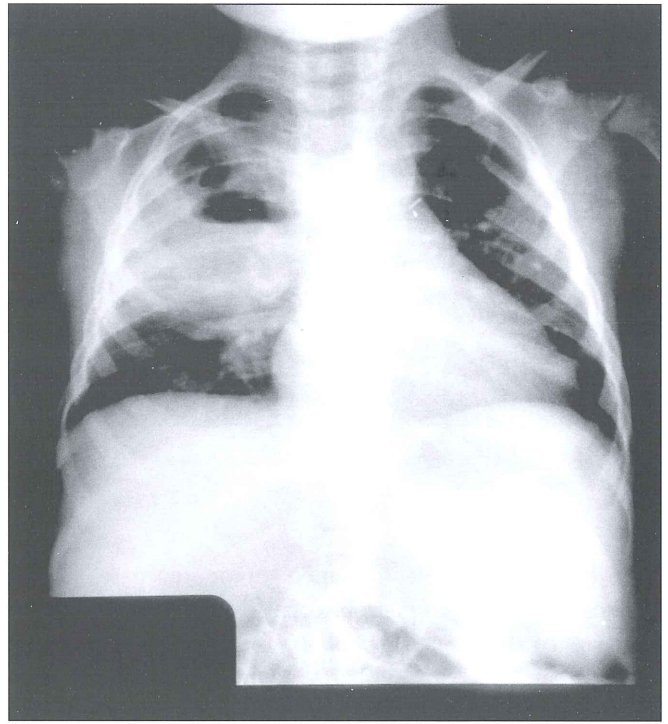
The control chest radiograph demonstrating cavitation and air-fluid level in the abscess.
